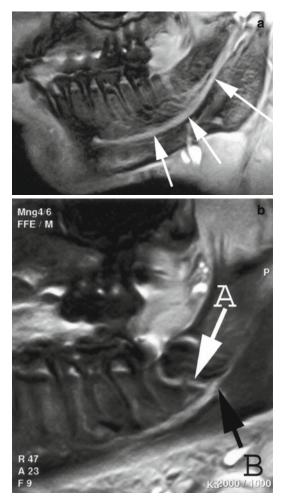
(a) Sagittal mandibular MRI image of a normal inferior alveolar nerve (*arrows*) (Adapted from Kress et al. [17], p. 1636). (b) Sagittal mandibular MRI image of a mandible fracture associated with the mesial aspect of the impacted third molar (A), showing continuity of the inferior alveolar nerve (B) but lack of detailed fascicular anatomy (Adapted from Kress et al. [17], p. 1636)
